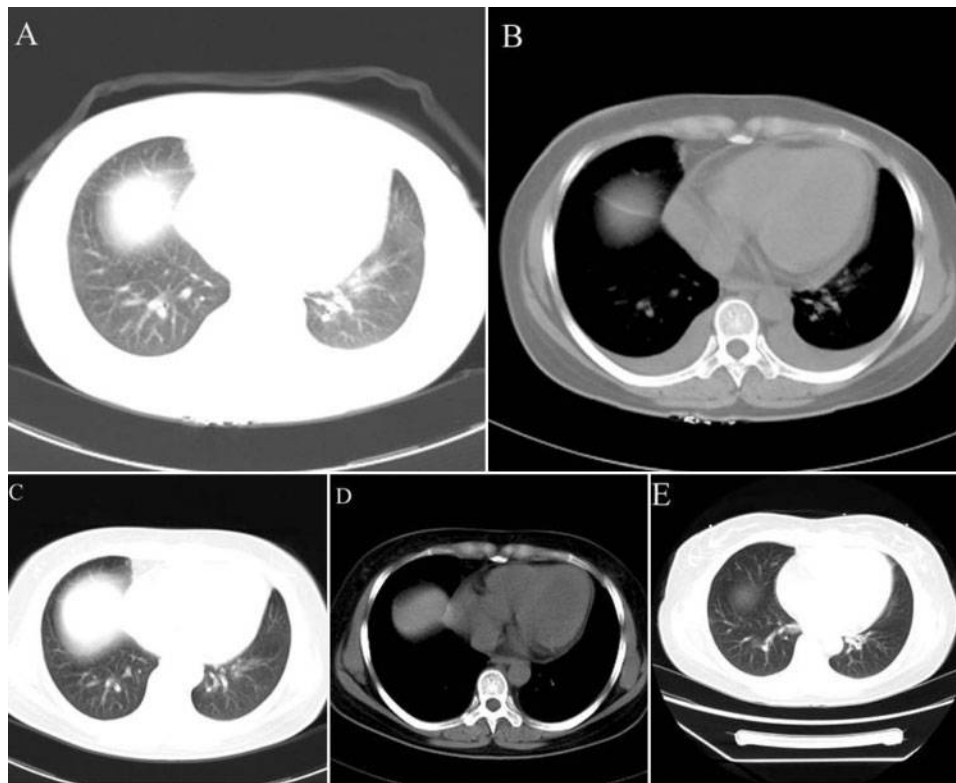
This patient had only fever, respiratory symptoms and abnormal chest HRCT without skin, liver and gut involvement on +89 days post-transplantation. Chest HRCT showed diffused interstitial and alveolar infiltrate (A) and bilateral pleural effusion accompanied by hydropericardium (B) at the onset. Chest HRCT showed diffused interstitial and alveolar infiltrate worsened (C) and worsened bilateral pleural effusion (D) after anti-infection for 1 week. Chest HRCT showed that intraparenchymatous infiltrate was obviously improved (E), hydropericardium and pleural effusion disappeared (F) after anti-GVHD for 10 days. Chest HRCT showed thickening interstitial markings and deranged vascular shadow after anti-GVHD for 95 days (G)
